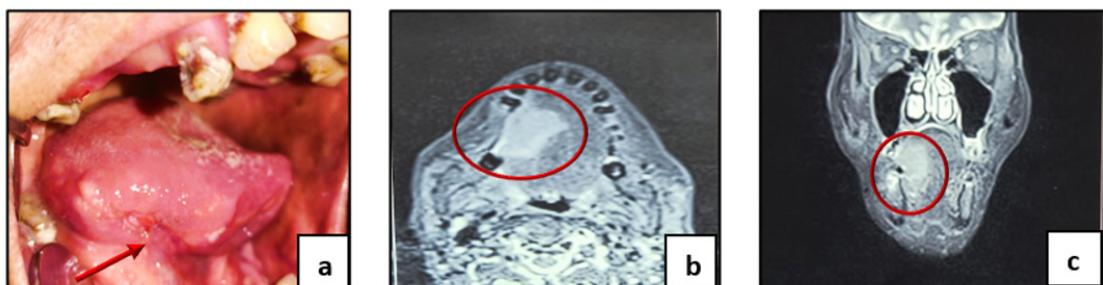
(a). Solitary ulcerative lesion on the right lateral aspect of tongue (red arrow). (b and c). Hyperdense area on the MRI infiltrating the genioglossus, hyoglossus and mylohyoid muscles encroaching in to the midline raphe (red encircled area).
